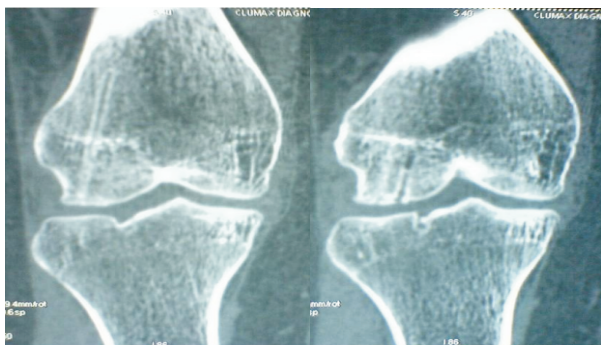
CT scan at 9 months post-op shows good union of OCD fragment
